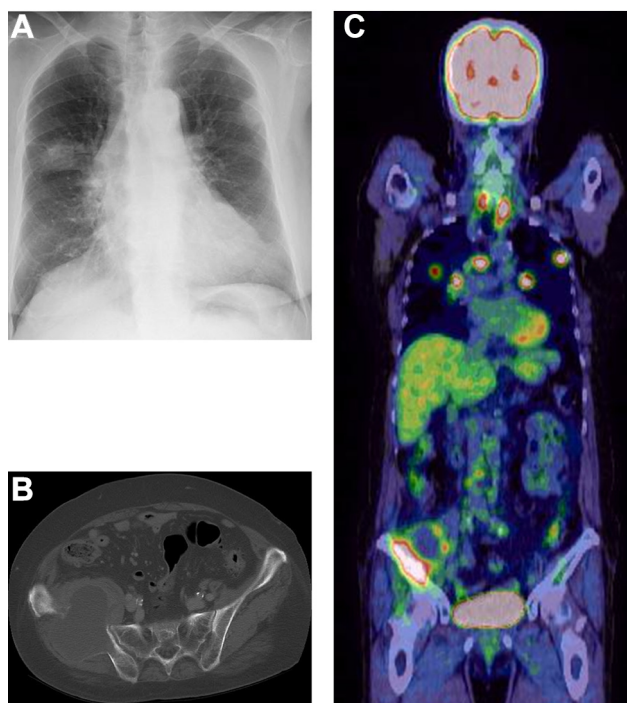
Initial imaging findings. A) Chest radiograph showing bilateral lung masses. B) Contrast-enhanced computed tomography (CT) indicating a large mass in the right iliac bone. C) Positron emission tomography (PET)-CT demonstrating widespread metastases in both lungs, mediastinum, and iliac bone.
